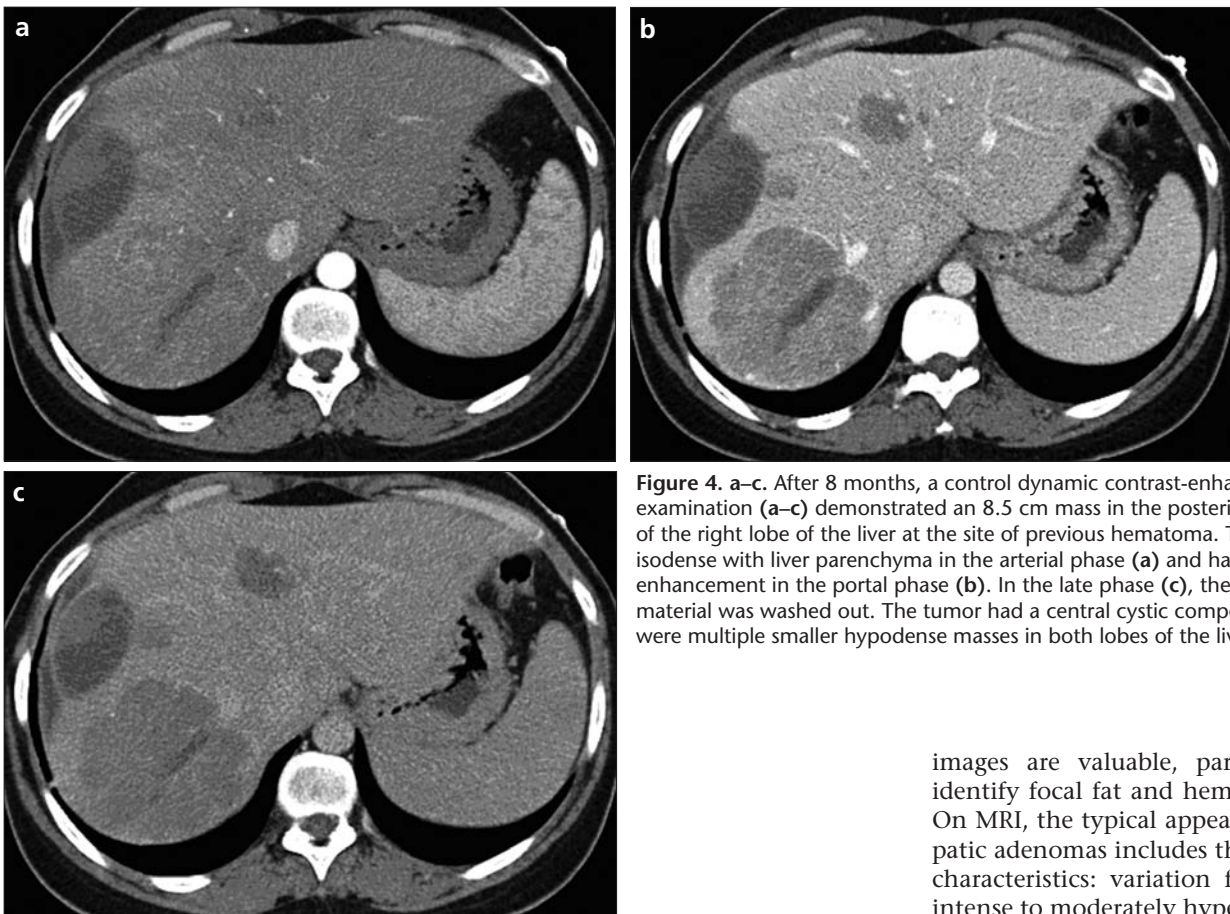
a–c. After 8 months, a control dynamic contrast-enhanced CT examination (a–c) demonstrated an 8.5 cm mass in the posterior segment of the right lobe of the liver at the site of previous hematoma. The mass was isodense with liver parenchyma in the arterial phase (a) and had contrast enhancement in the portal phase (b). In the late phase (c), the contrast material was washed out. The tumor had a central cystic component. There were multiple smaller hypodense masses in both lobes of the liver.
